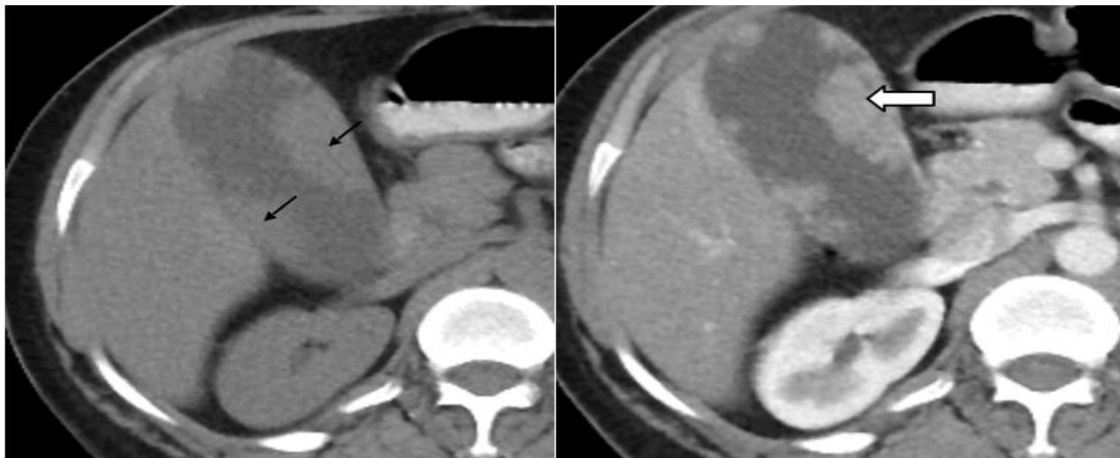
40 years old, female: Plain CT Scan abdomen shows multifocal small polypoidal intraluminal soft tissue lesions (black arrow) in fundus and body region, hypodense to liver and denser than bile. Figure 4b- Contrast enhanced CT Scan abdomen shows presence of multifocal small polypoidal intraluminal homogeneously enhancing soft tissue lesions (white arrow) in fundus and body of gall bladder.
